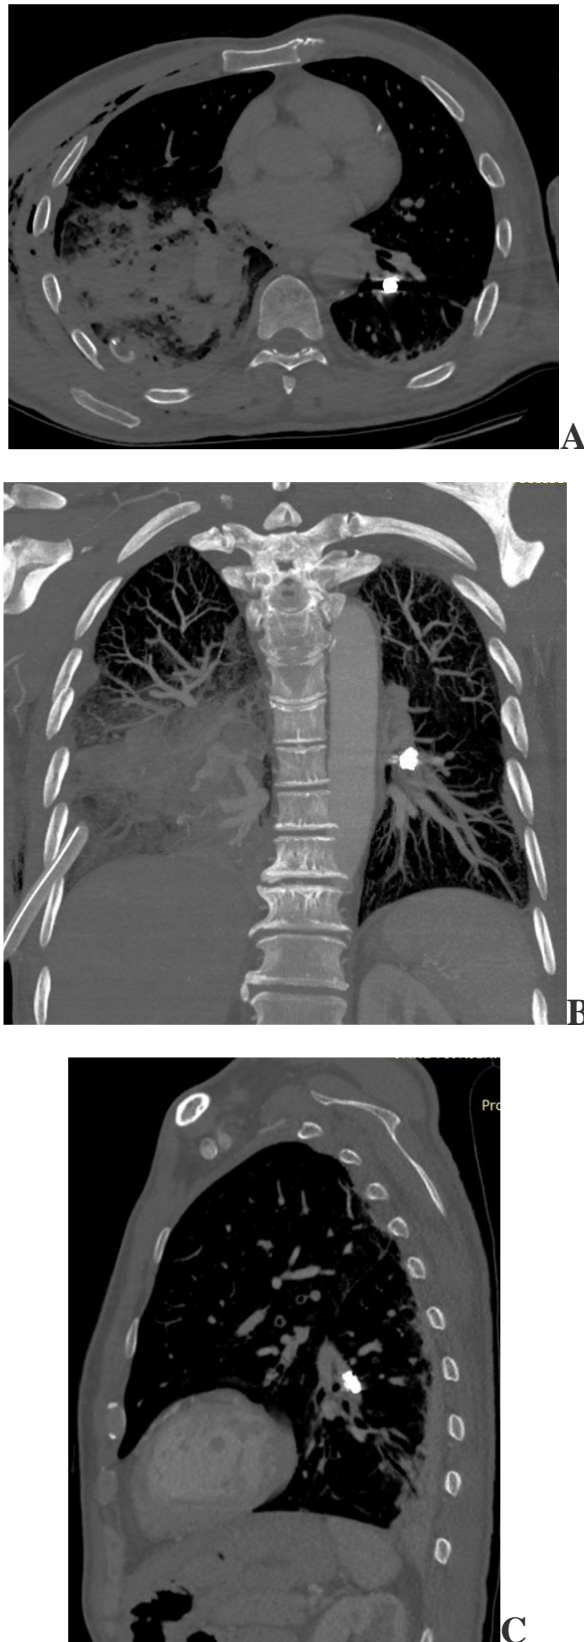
Spiral CT angiography of the pulmonary arteries: a metal fragment in the segmental branch of the left pulmonary artery (migration of the fragment with the right pulmonary artery during surgery). A – axial plane; B – coronal plane; B – sagittal plane.
